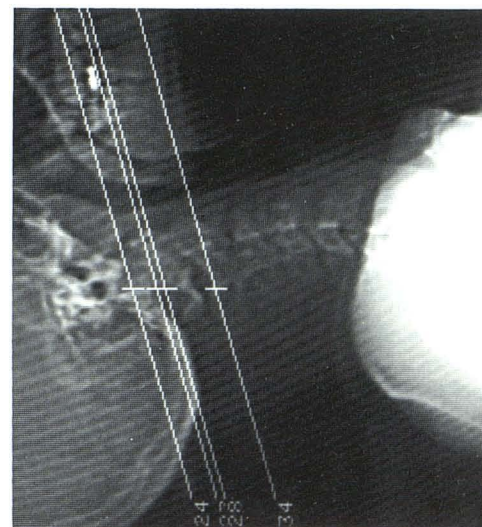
ScoutView in comfortable hyperextension shows plane of CT slices perpendicular to vertical axis of C2.
